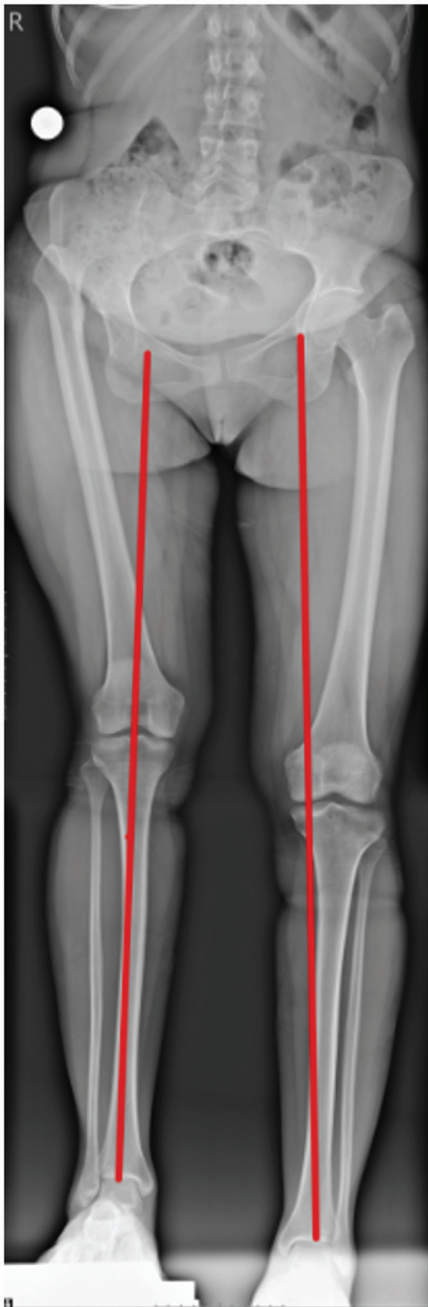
Measurements of leg length on full-length standing anteroposterior radiograph
